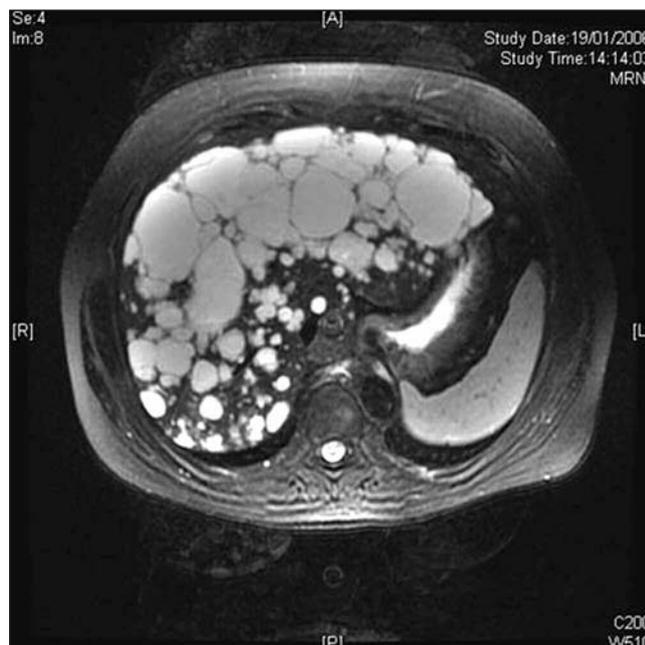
T2-weighted sequence with fat saturation in which the lesions are hyperintense, similar to CSF.
